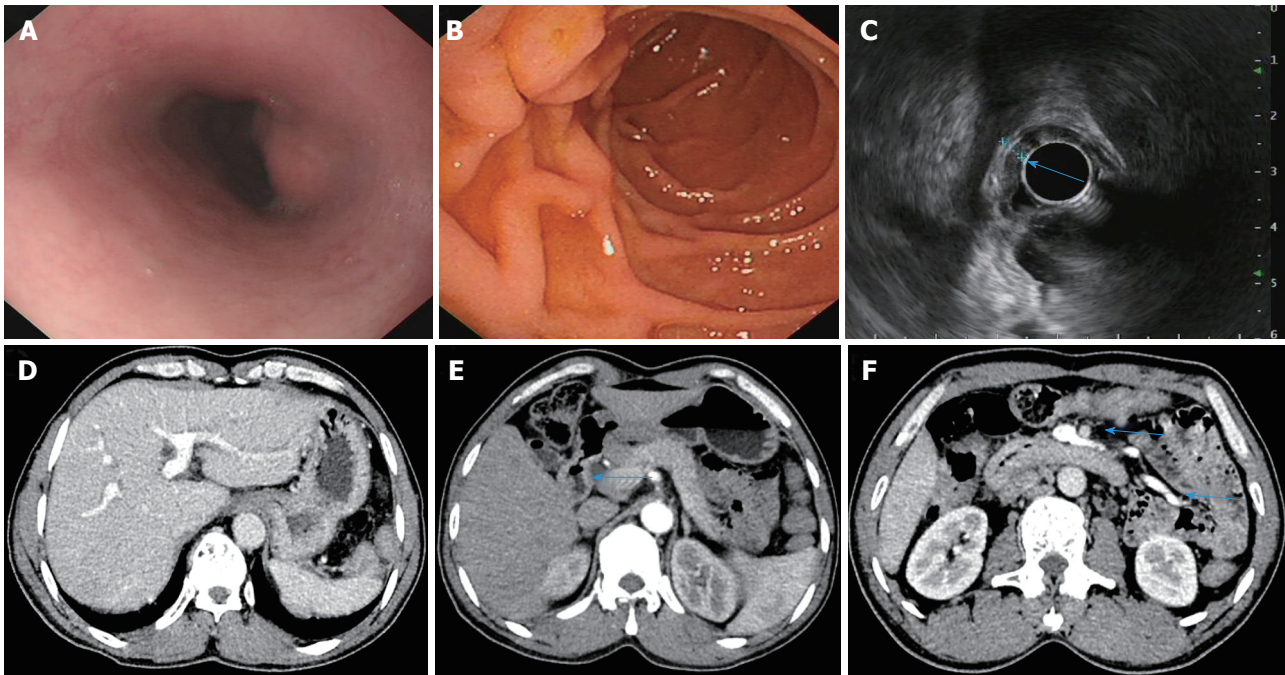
Following administration of praziquantel, the patient with acute *Schistosoma japonicum* infection received a complete check-up at the follow-up visit. A, B: Upper gastrointestinal endoscopy showing protrusive lesions of the esophagus (A) and normal mucosa in the descending duodenum (B); C: Endoscopic ultrasonography revealing slight thickening and normal layer of the descending duodenal wall; D-F: Dynamic abdominal computed tomography showing homogeneous hepatic perfusion on the portal phase (D), slight thickening of the descending wall (E, arrow), shrinkage of the swollen mesentery to normal size (F, arrow), and disappearance of ascites.
